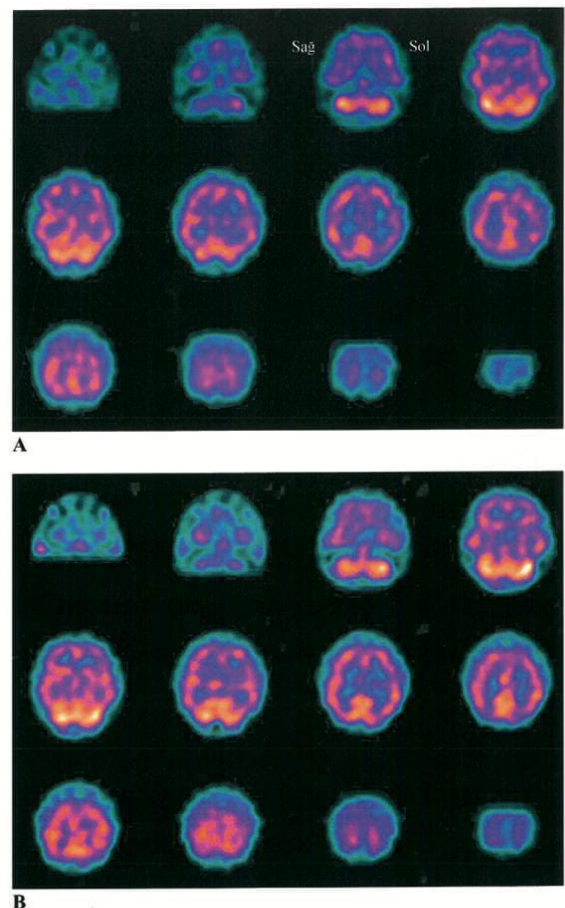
(A, B). In Patient 9, widespread hypoperfusion was observed in the brain during ictal stage (A) with axial section by Tc-99m HMPAO SPECT. The same patient showed continuation of ictal hypoperfused areas in interictal period as well, with relative increase in blood perfusion (B)
